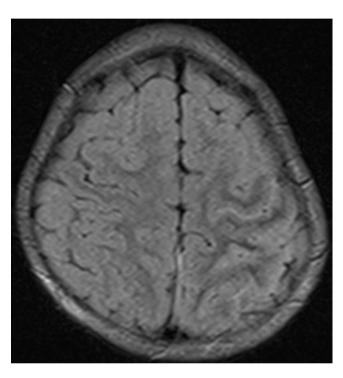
T2/fluid-attenuated inversion recovery-weighted magnetic resonance imaging the brain showing high signal intensity in the left temporal and parietal lobes.
